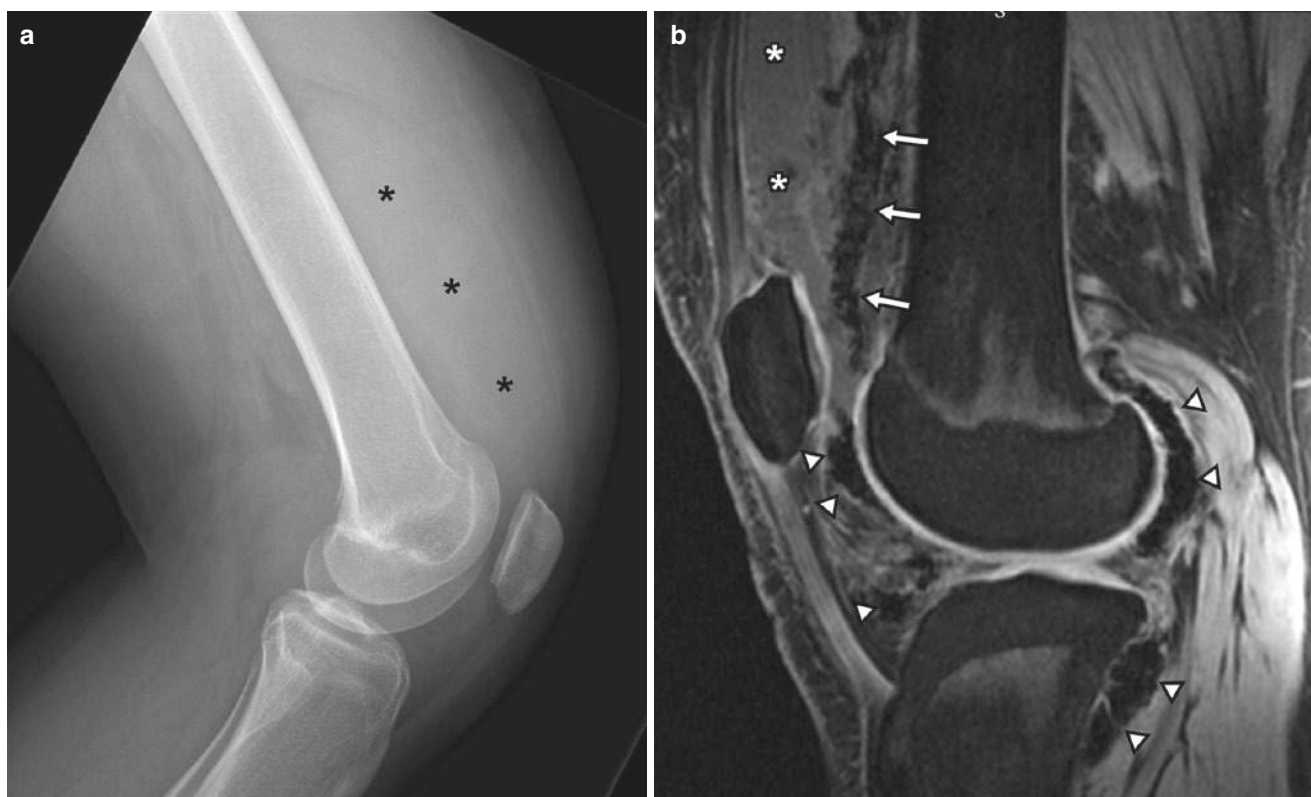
Sixteen year-old girl with pigmented villonodular synovitis of the knee. The patient had a 1–2 year history of increasing knee swelling and pain. (a) Lateral radiograph shows a very large effusion within the suprapatellar pouch (*asterisks*). (b) Sagittal water selective (WATS)
